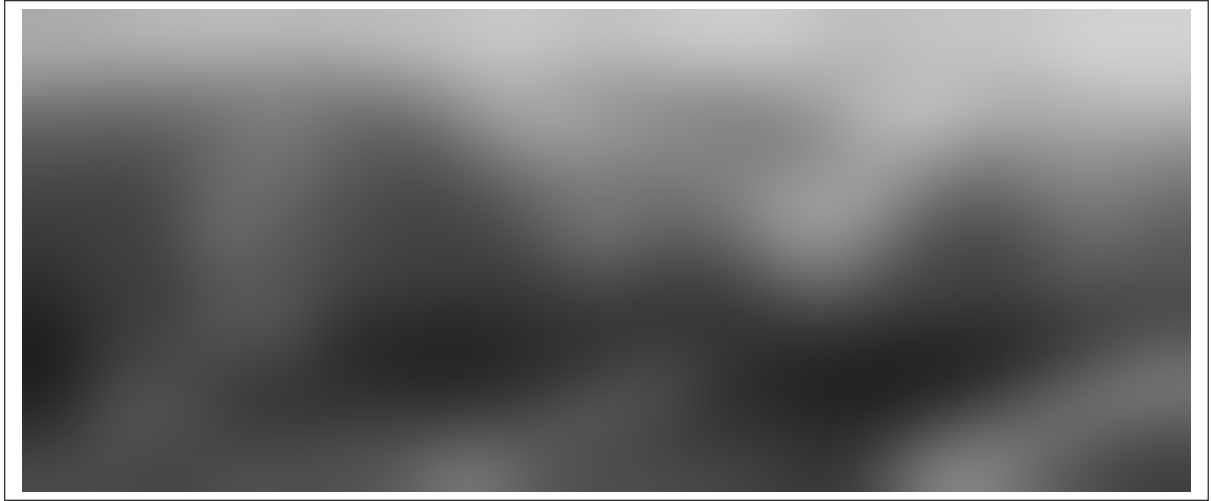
Smoothed ultrasound image before applying the optical flow algorithm
